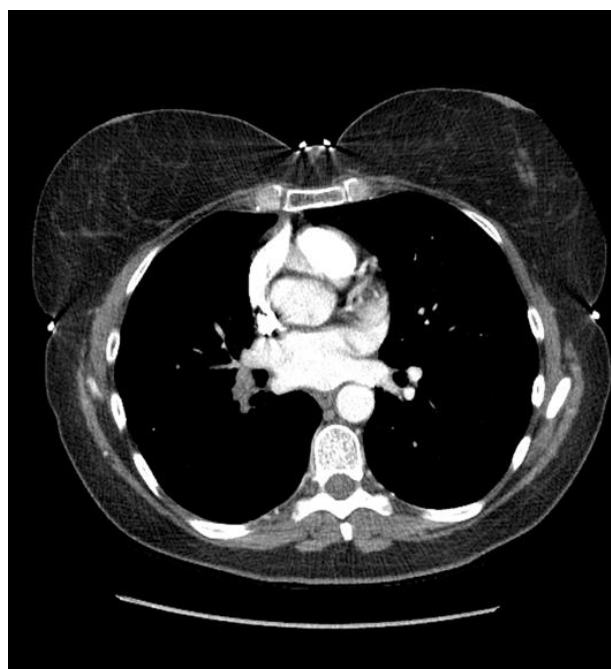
Axial CT aortogram image demonstrating luminal narrowing of the aortic arch and its major branches, consistent with large-vessel vasculitis.
